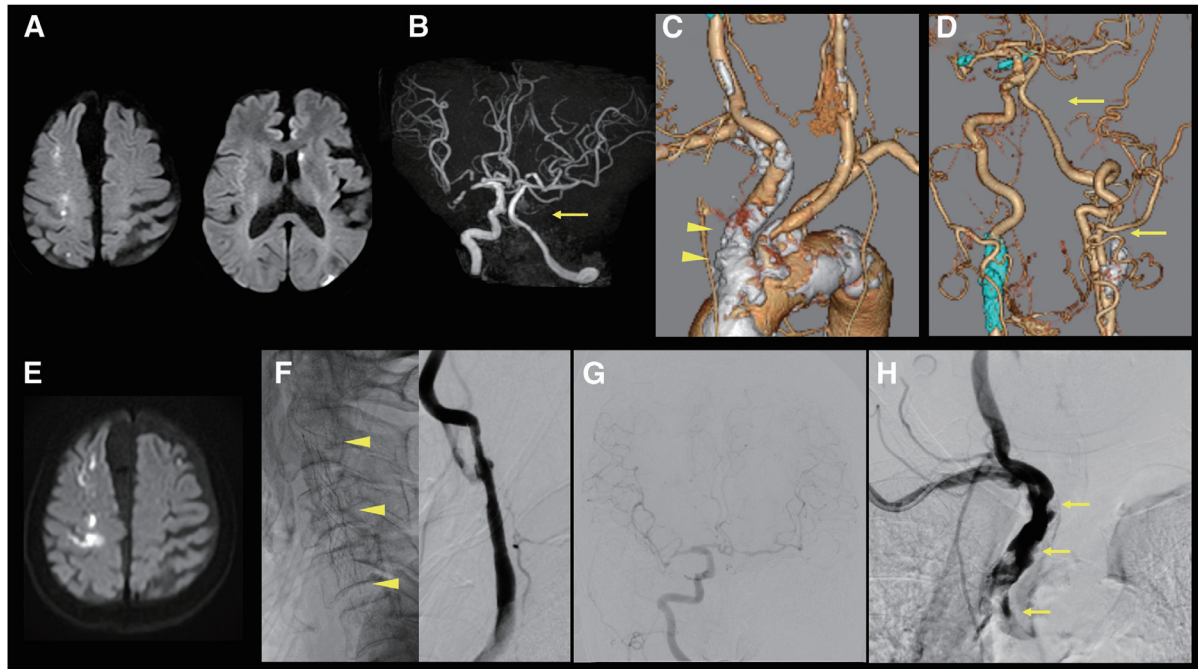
Imaging findings in case 2. (A) Diffusion-weighted MRI on admission. (B) Head MRA shows the absence of the left intracranial ICA (arrow). (C) Neck CTA shows diffuse plaque in the IA (arrowheads). (D) Neck and Head CTA shows suspected chronic occlusion of the left ICA (arrows). (E) Diffusion-weighted MRI on day 2. (F) Plain radiography (left) and angiographic image (right) of the right common carotid artery. Arrowheads indicate the carotid artery stent. (G) Intracranial view of the right common carotid angiography. (H) IA angiography demonstrated a shaggy appearance throughout the entire IA (arrows).
